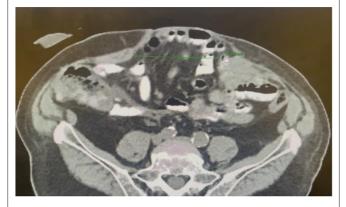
A CT scan shows a Midline hernia and no Parastomal hernia but a non-clinical bulge.
